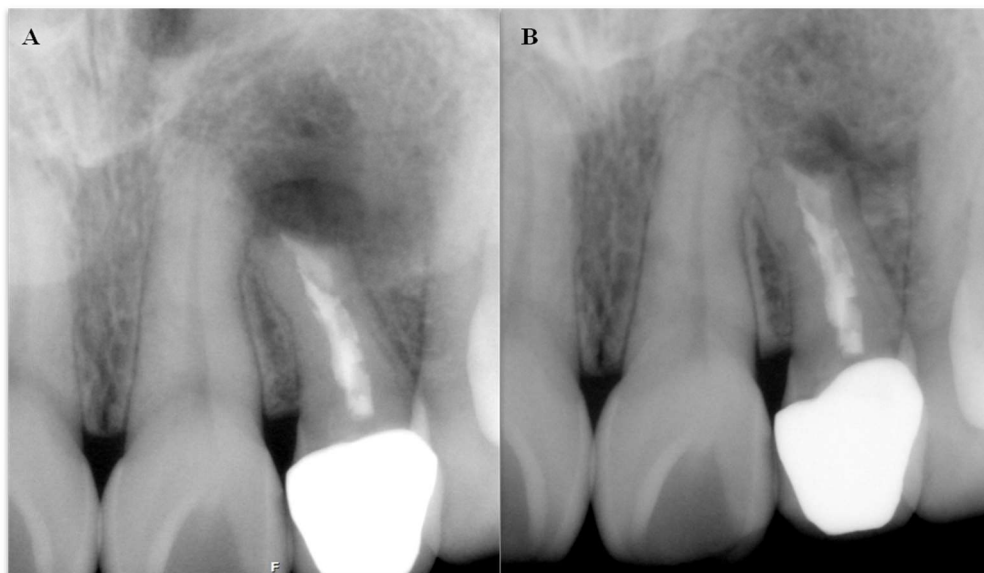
Maxillary lateral incisor radiographically assessed as incomplete healing 1 year after apical microsurgery. (A) Postoperative and (B) 1-year follow-up.
